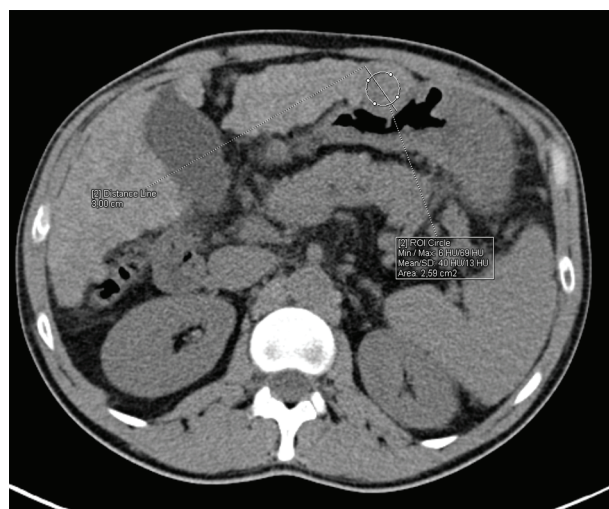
Native CT (pre-procedure) – the finding in the left lobe (30 mm) of the liver is presented with an average measured density of up to 40 Hounsfield units (HU).
